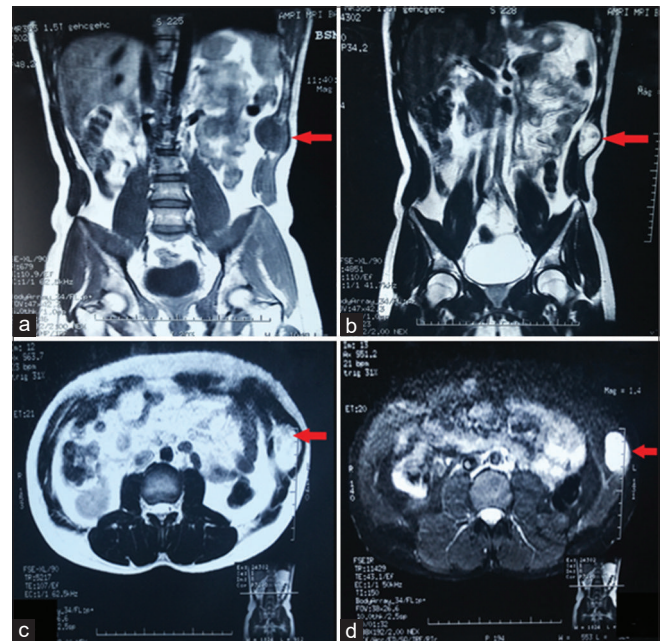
T1-weighted (T1WI) coronal magnetic resonance imaging (MRI) showing (a) a iso to hypointense lesion (red arrow). (b) A heterogeneously hyperintense lesion (red arrow) on T2WI axial MRI. (c) A heterogeneously hyperintense lesion (red arrow) on T2WI coronal MRI. (d) MRI with fat suppression (inversion recovery) sequence axial view showing hyperintense mass over the abdominal wall (red arrow)
